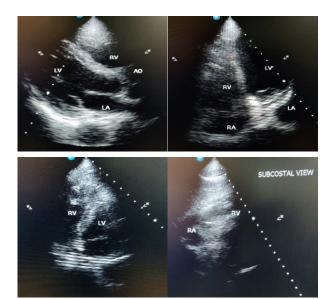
Echocardiogram images showing dilated RV with outpouching in RV (arrow)
